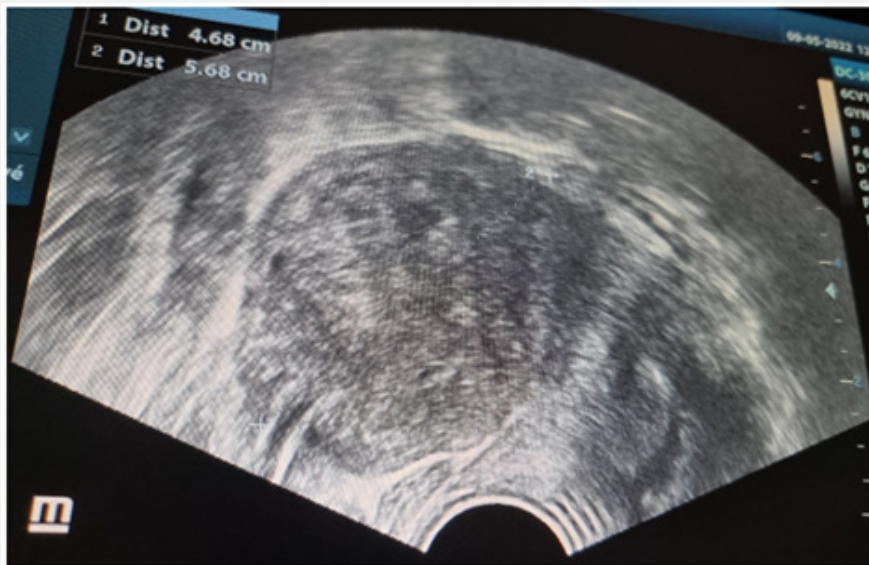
Uterine fibroid measuring 5,68 cm / 4,68 cm on pelvic ultrasound.
